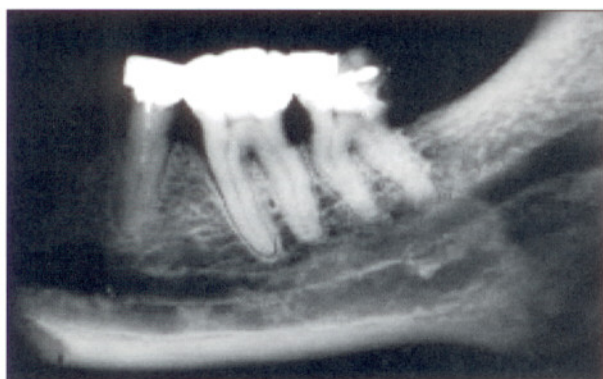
Radiograph of mandibular fragment
